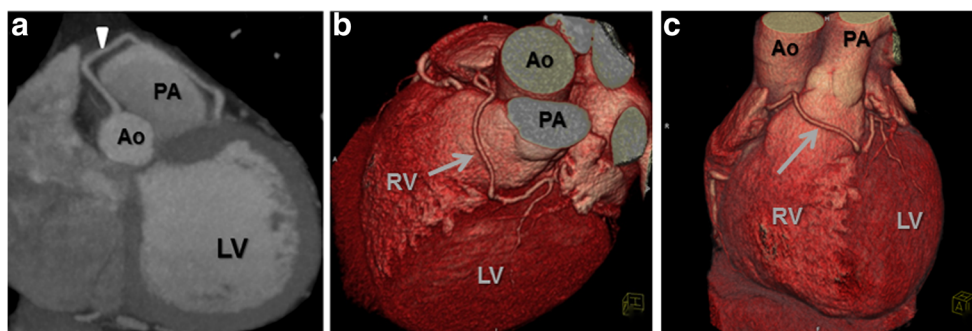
Anomalous left main coronary artery arising from the right sinus of Valsalva and coursing anterior to the pulmonary artery discovered incidentally on coronary CTA during evaluation for atypical chest pain in a 47-year-old woman. a The maximum intensity projection image demonstrates the left main coronary artery arising from the right sinus of Valsalva with a course anterior to the pulmonary artery (prepulmonic)
